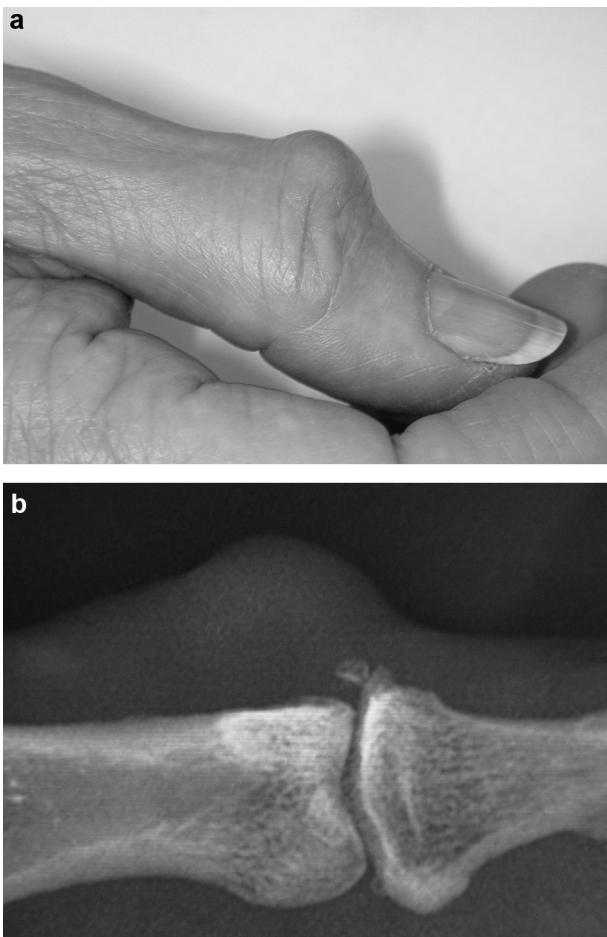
Mucous cyst of the interphalangeal joint of the right thumb. Clinical appearance (a). X-ray: mild osteoarthritis of the interphalangeal joint with osteophyte formation (b).
